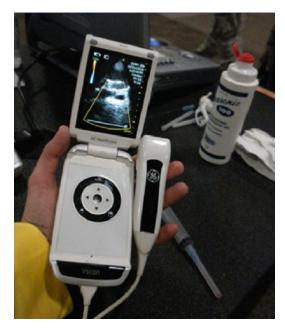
Ultrasound equipment has evolved to become smaller, portable, yet with excellent image quality, making it available to many physicians in the care of their patients
